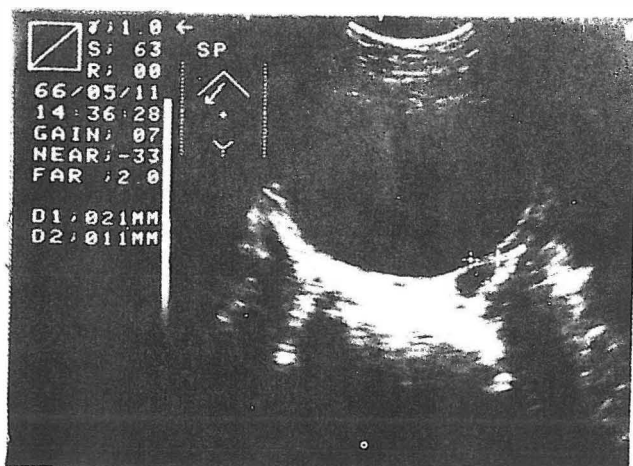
Sonography of the ovaries for evaluation of the diameter of the follicles.
